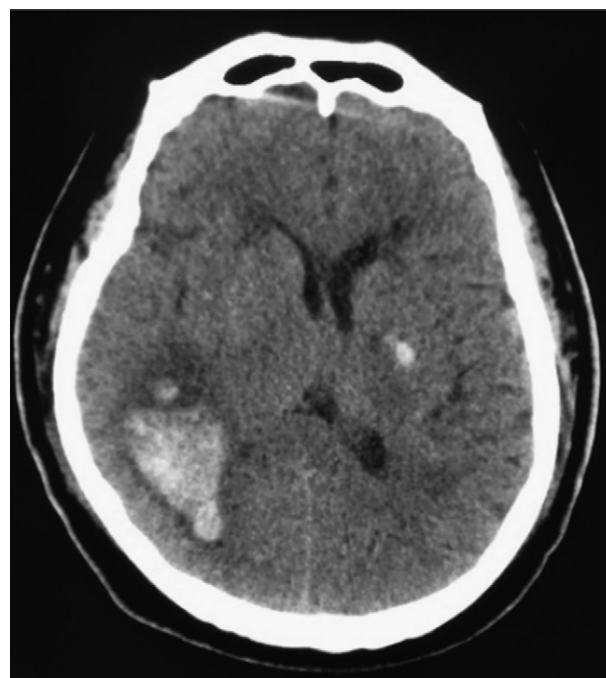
Cranial CT 1 h after rtPA thrombolysis shows hemorrhage in the right temporal lobe and spotted hemorrhage in the left basal ganglia.
